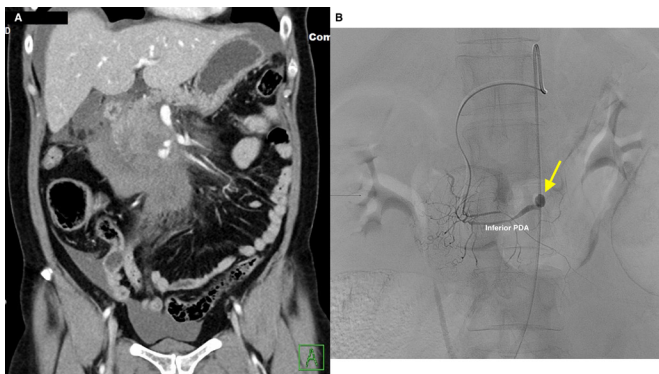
(A) CT coronal section: large retroperitoneal haematoma around the duodenum and pancreas. (B) Angiography: aneurysm (arrow) along the inferior pancreaticoduodenal artery (PDA).
